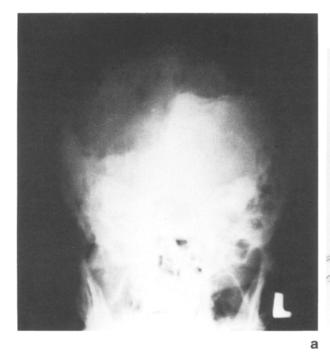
a) Skull X-ray performed 3 years after surgery showing the extent of the defect – note the radiolucency of the prothesis. b) The photograph of the patient 3 years after surgery – the cosmetic result is excellent, the right frontal branch of the facial nerve was damaged during surgery
